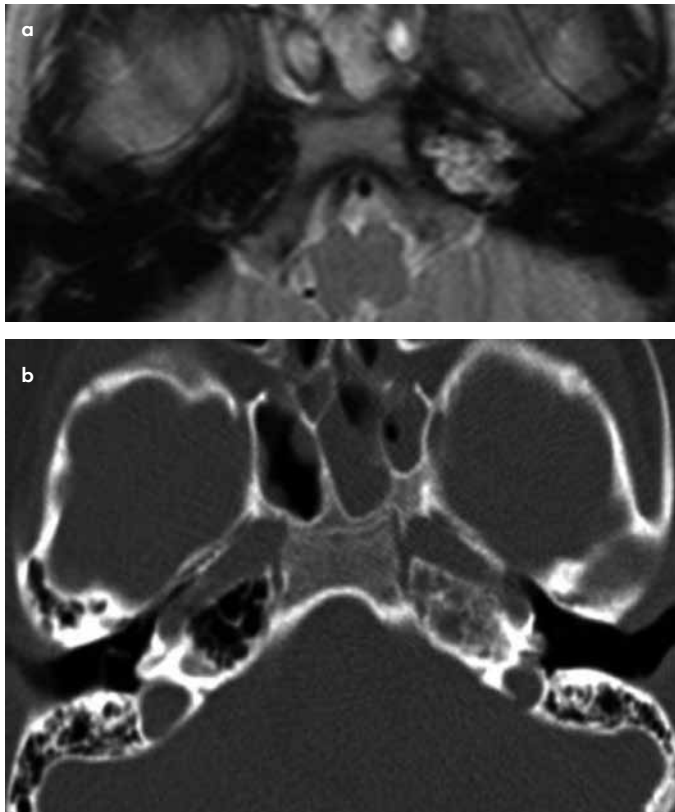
a, b. Petrous apex effusion. On T2-weighted image, there is a high T2 lesion in the left petrous apex (a). HRCT of the temporal bone reveals opacification of the left petrous apex with the preservation of air cells (b). Absence of expansion and presence of trabecular thinning suggest the diagnosis of effusion.
